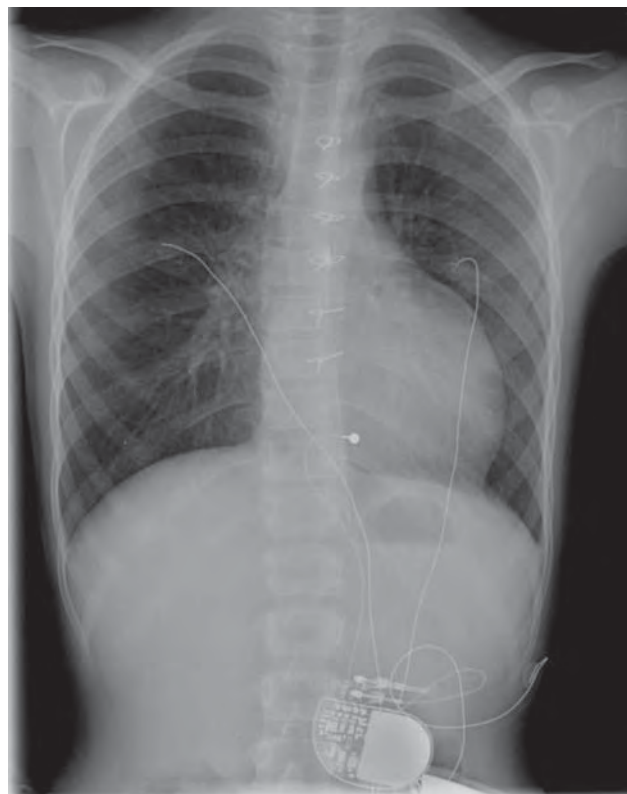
Single view anterior-posterior chest X-ray. Note the straight left heart border, sternal wires, and single lead epicardial pacemaker.
